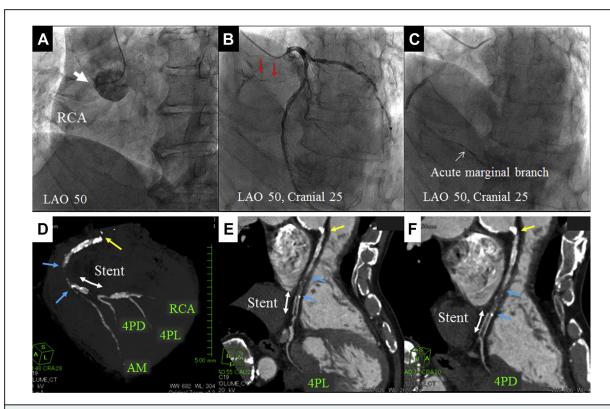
Coronary Angiography and Computed Tomography Angiography
